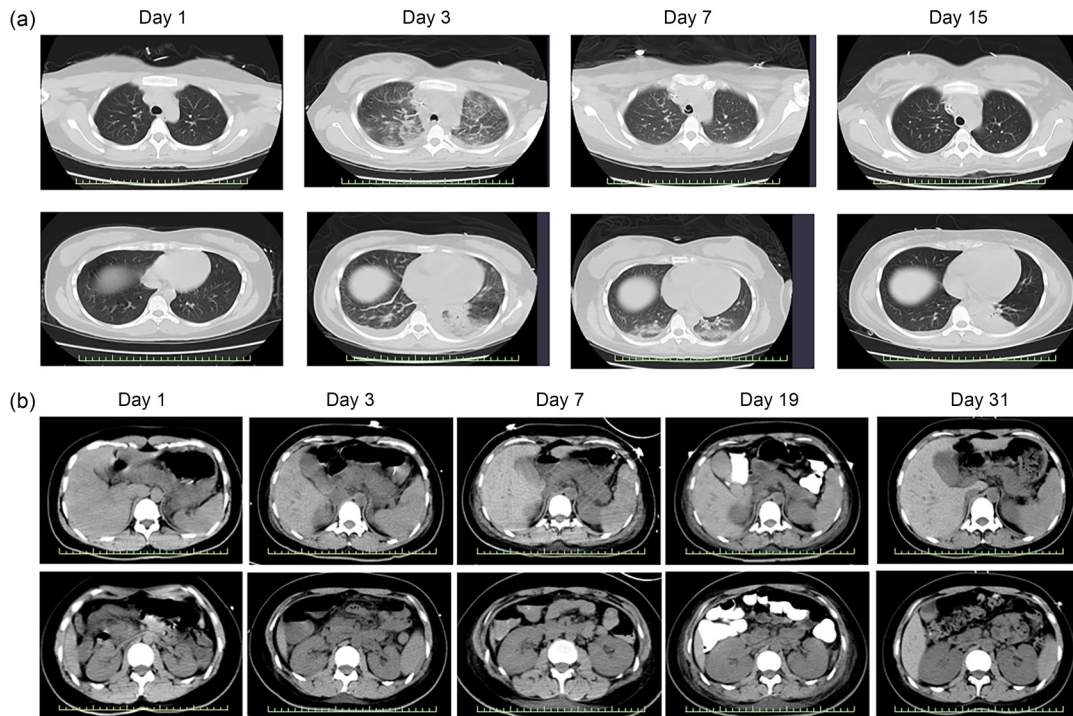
Changes in the patient's lung and abdominal computed tomography (CT) imaging. (a) Lung CT scans on Days 1, 3, 7, and 15. Z slices: -80 mm (top) and -135 mm (bottom). (b) Abdominal CT scans on Days 1, 3, 7, 19, and 31. Z slices: -78 mm (top) and -150 mm (bottom).
